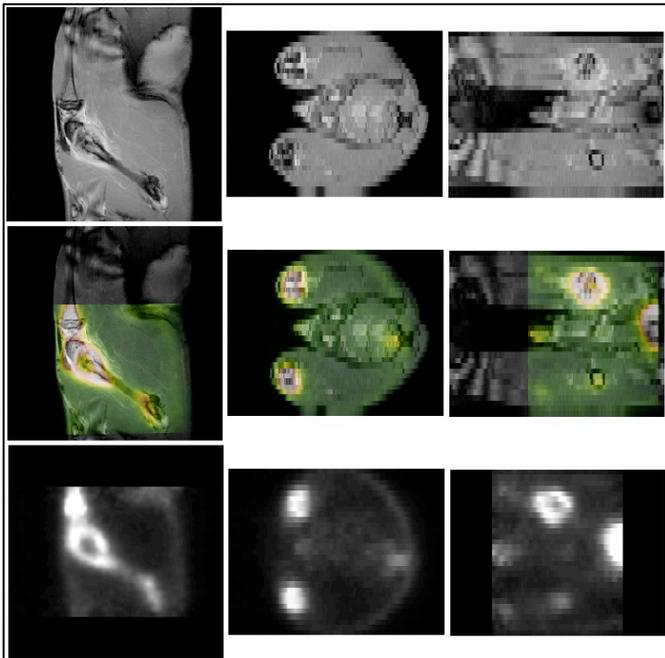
Example of successful PET-MRI registration using MRBIH and PCA initialization
